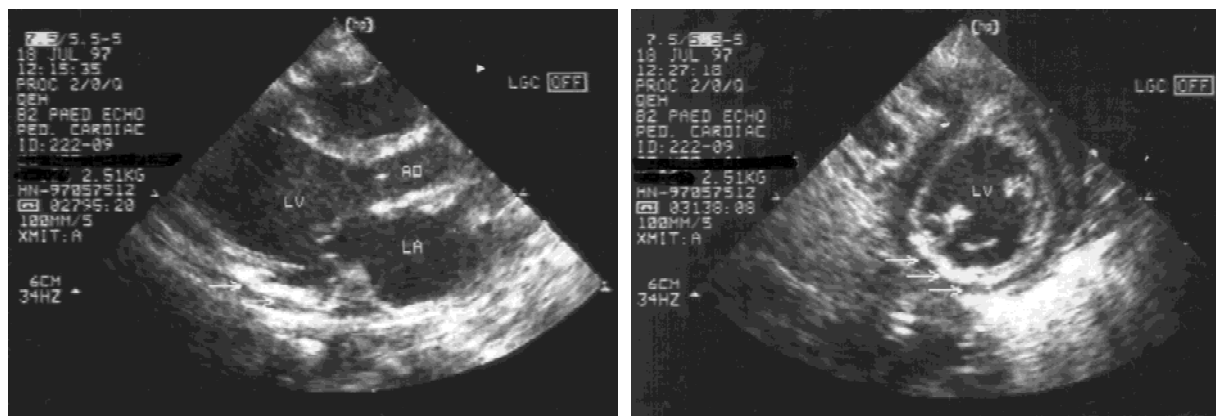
Echocardiography (Left, parasternal long axis view; right, parasternal short axis view), performed at 4 weeks of age, demonstrated echodense areas over the posterobasal region of left ventricle and part of the papillary muscles of the mitral valve. AO, aorta; LA, left atrium; LV, left ventricle.
